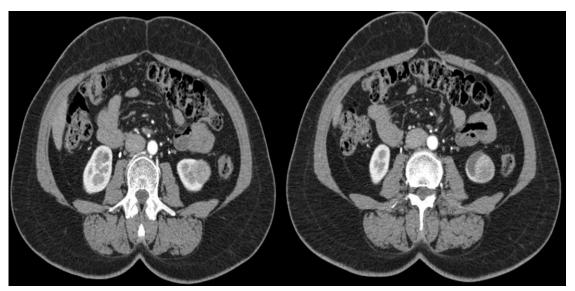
Computed tomography (CT) showing an exophytic, well defined solid mass of regular contours on the lower pole of the left kidney, with arterial phase enhancement.
